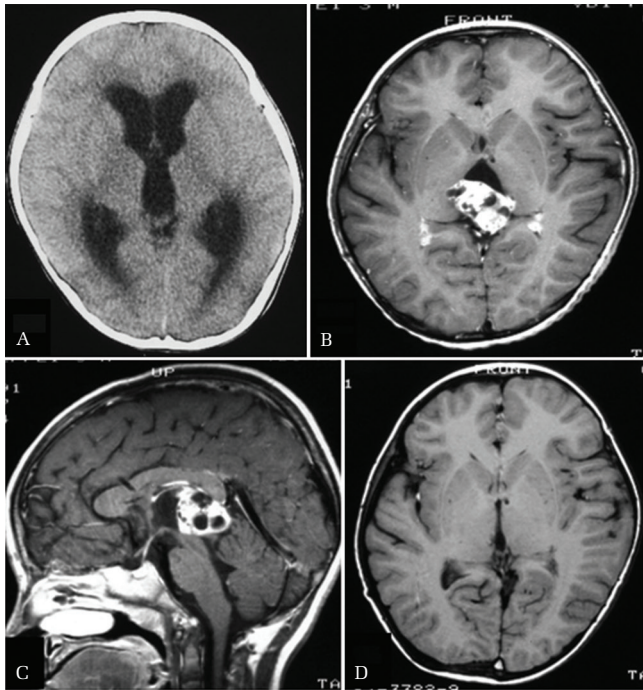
Neuroimaging findings at the first presentation. A: Preoperative computed tomography scan demonstrating severe hydrocephalus. B and C: Axial (B) and sagittal (C) T₁-weighted magnetic resonance (MR) images with gadolinium on admission demonstrating a heterogeneously enhanced tumor in the pineal region. D: Postoperative T₁-weighted MR image with gadolinium demonstrating complete resection of the pineal tumor.
